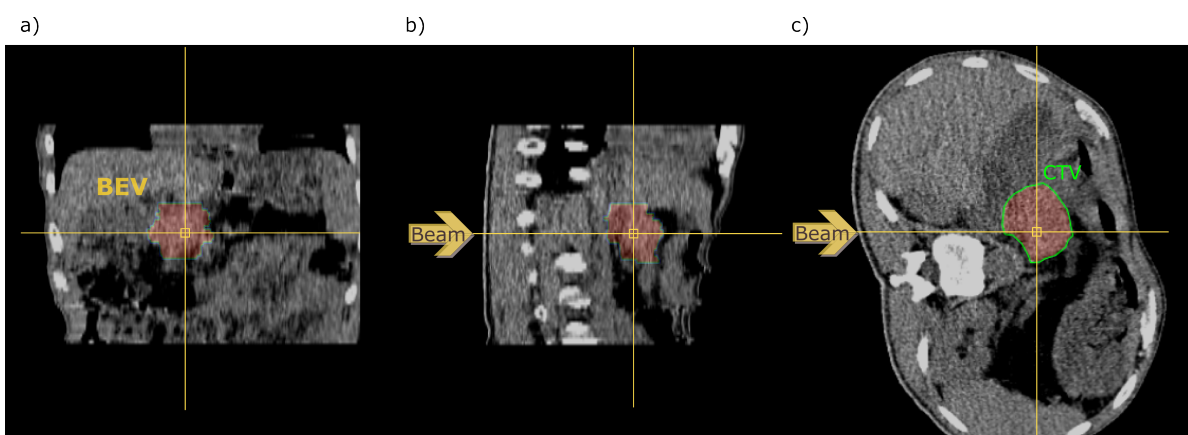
Example of the BEV rotation of a CT for an oblique posterior beam. The module $MVL_{CT-Veri}$ displays the CT in the three new axis after rotation, where a) correspond to the BEV, and b) and c) to the other two directions (x, y) with the beam always coming from the left side.
